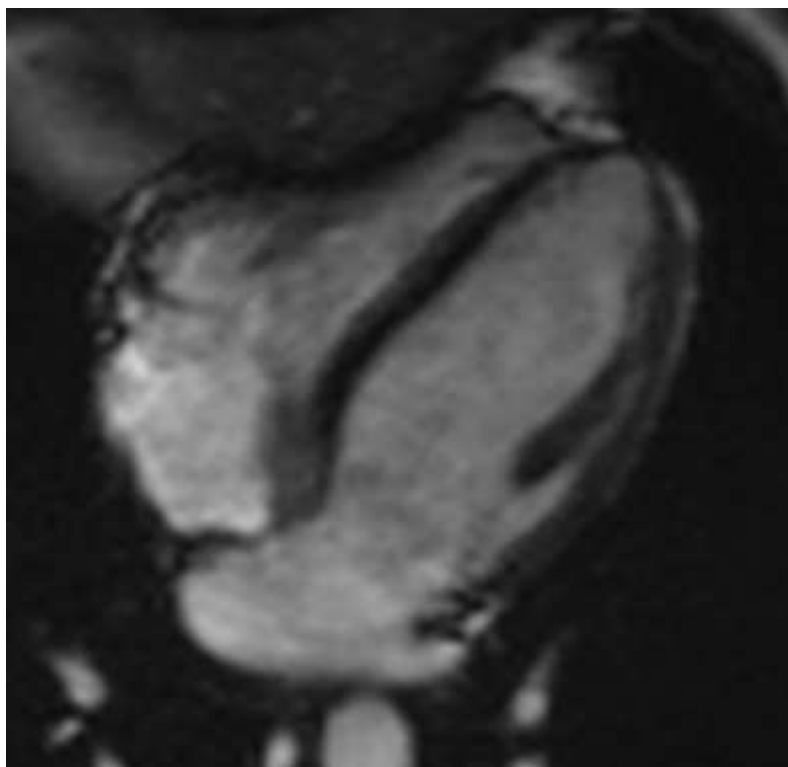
Cardiac magnetic resonance imaging (CMR) shows a well-defined RA mass
